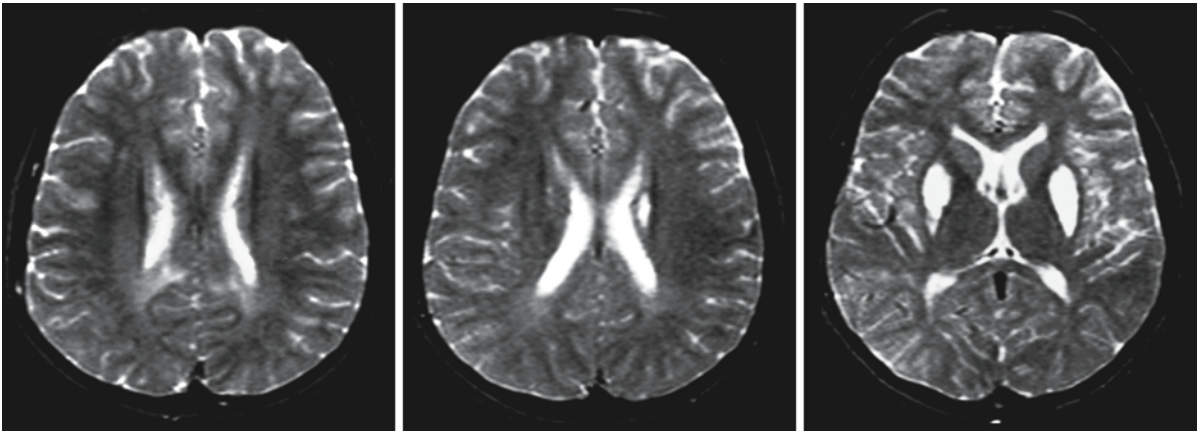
In this 9-year-old boy with SSPE, MRI initially showed only a few moderately abnormal white matter lesions in the centrum semiovale. The MRI in this figure was performed 7 months later, when signs of neurological dysfunction were
